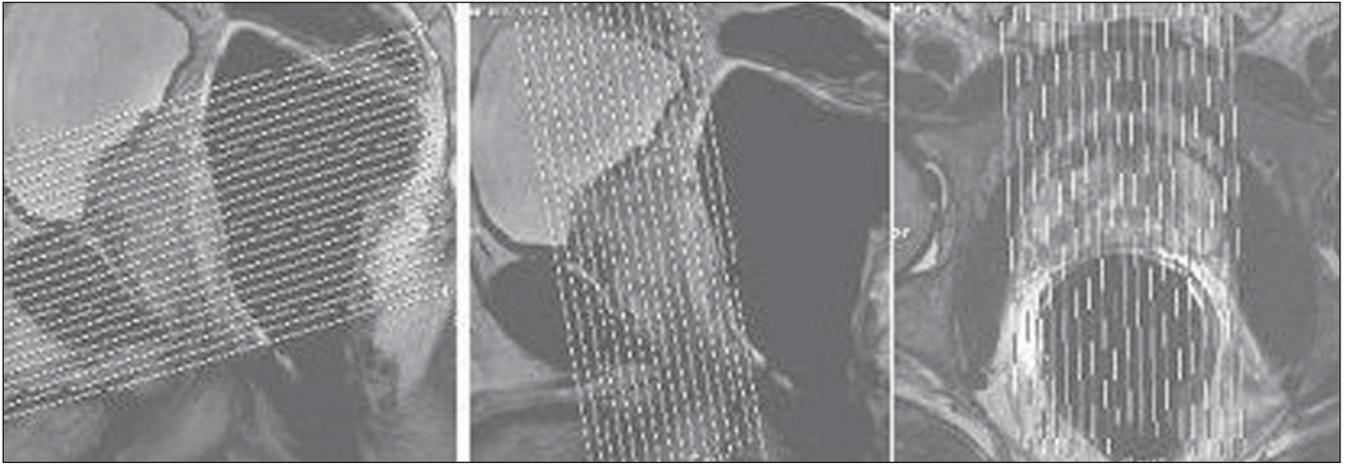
Programming of MRI of prostate. Programming representation in the axial, coronal, and sagittal planes.
